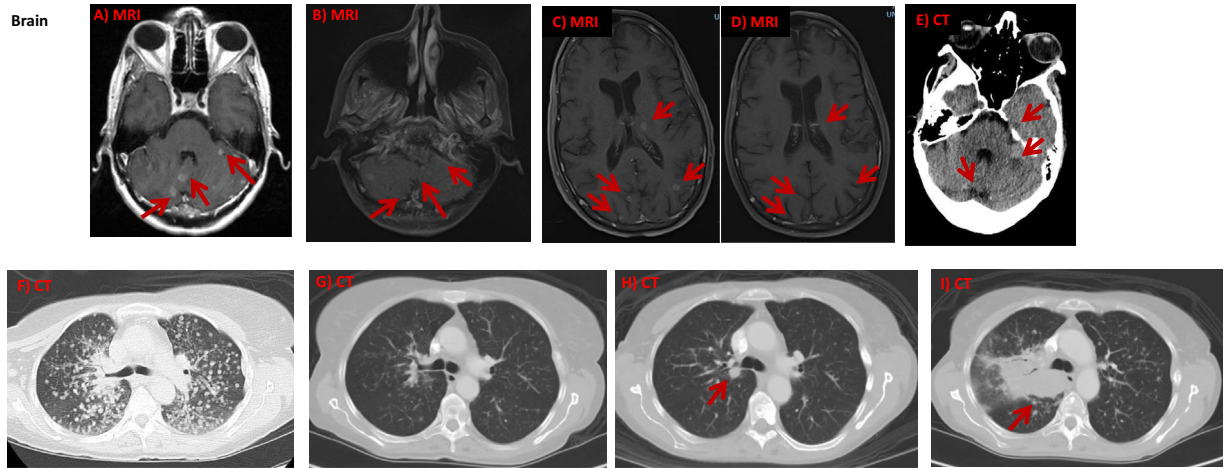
Chronology of treatment, response, molecular pathology, and imaging. Images A and F reveal the pretreatment baseline scans with extensive bilateral miliary metastases in the lung; B and G, the 4-week post-pozitotinib scans; C, the flare 3 weeks after pozitotinib discontinuation; D, the treatment response after reinitiation of pozitotinib on the EAP; E, the second flare 2 weeks after discontinuation of pozitotinib EAP; H, the development of a new RUL nodule 5 months and 19 days after 12 mg PO daily of pozitotinib; I, progression of the right lung disease 12 weeks after 12 mg PO daily of pozitotinib. CGP, comprehensive genomic profiling; CT, computed tomography; D/C, discontinued; EAP, expanded access protocol; MRI, magnetic resonance imaging; PD, progressive disease; PO, orally; PR, partial response; RUL, right upper lobe.
